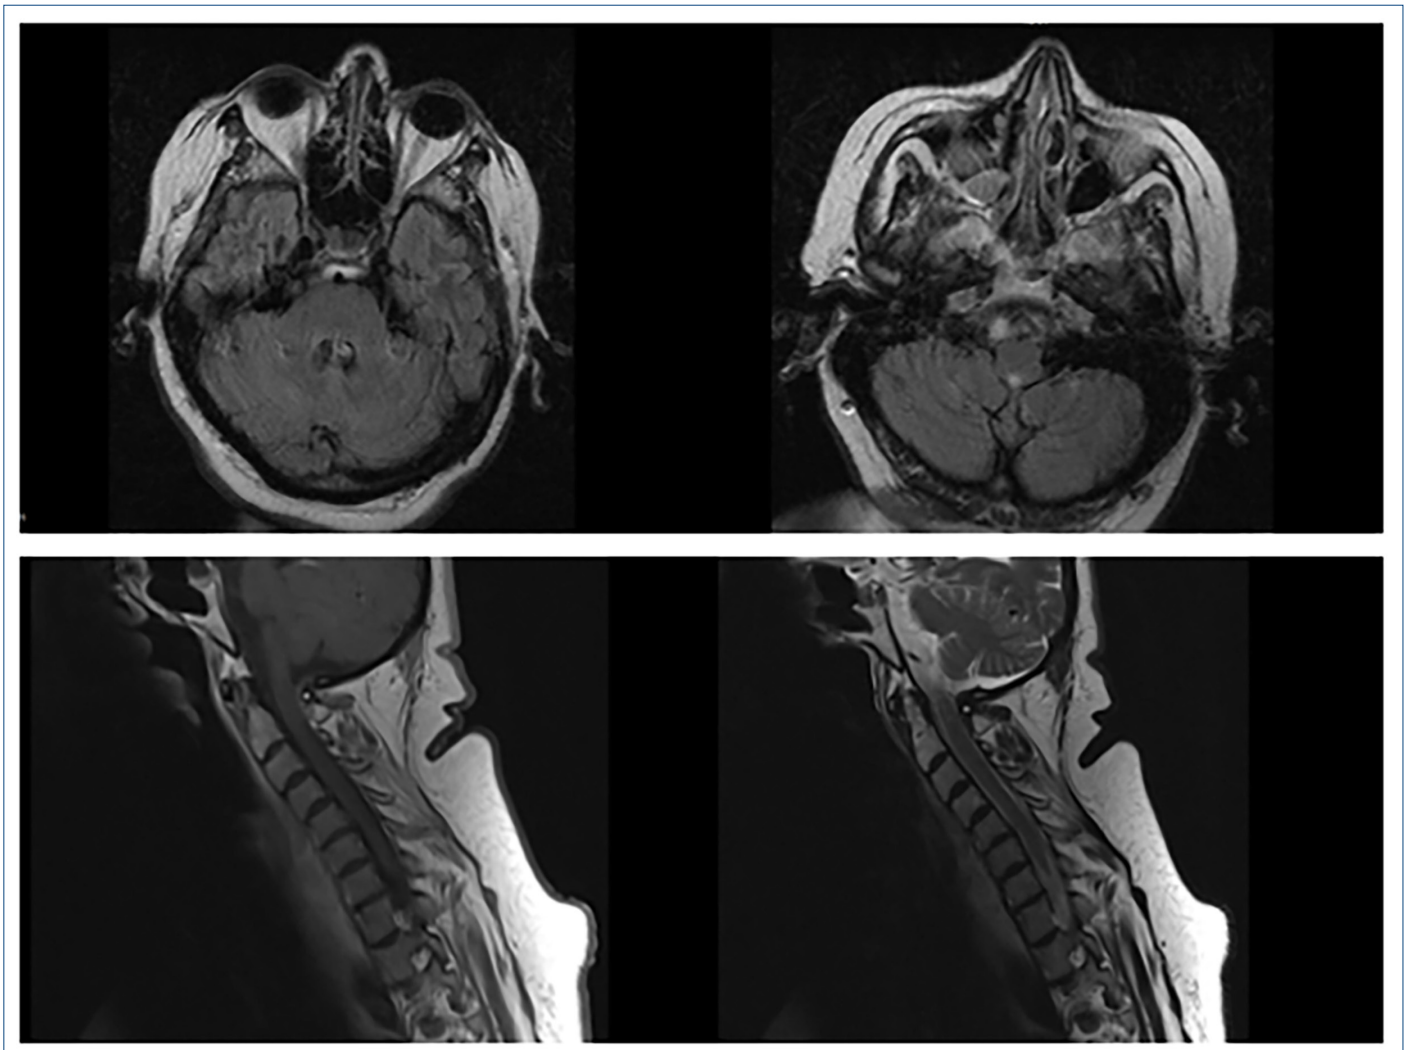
Brain and cervical magnetic resonance imaging scans of the patient after radiotherapy. Brainstem can be seen on the first line, and cervical medulla spinalis on the second line. There are no significant findings on the scans.
